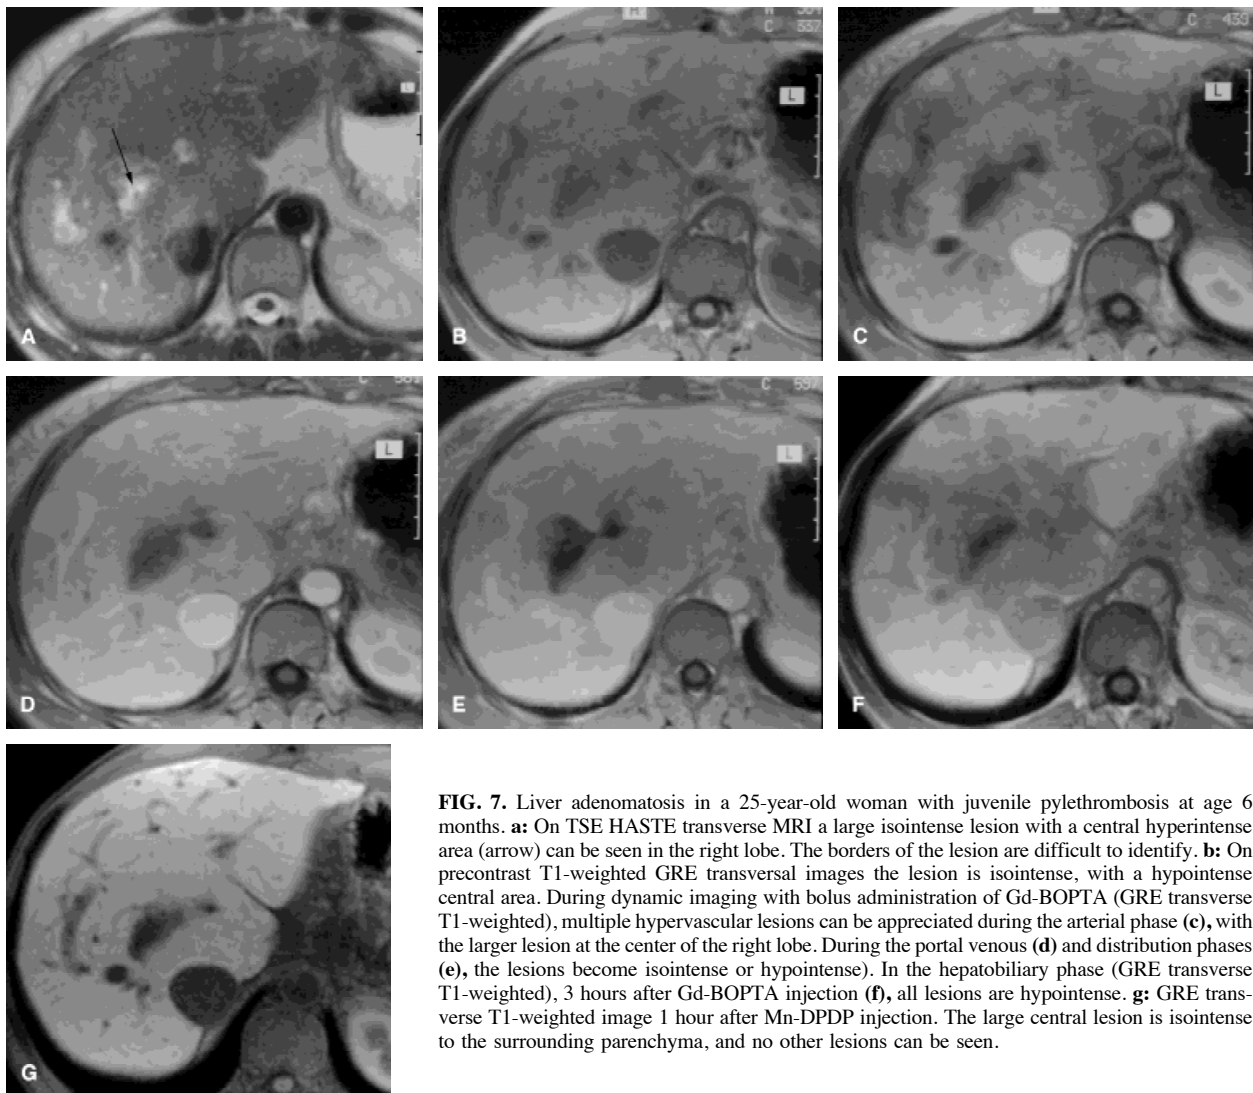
Liver adenomatosis in a 25-year-old woman with juvenile pylethrombosis at age 6 months. a: On TSE HASTE transverse MRI a large isointense lesion with a central hyperintense area (arrow) can be seen in the right lobe. The borders of the lesion are difficult to identify. b: On precontrast T1-weighted GRE transversal images the lesion is isointense, with a hypointense central area. During dynamic imaging with bolus administration of Gd-BOPTA (GRE transverse T1-weighted), multiple hypervascular lesions can be appreciated during the arterial phase (c), with the larger lesion at the center of the right lobe. During the portal venous (d) and distribution phases (e), the lesions become isointense or hypointense). In the hepatobiliary phase (GRE transverse T1-weighted), 3 hours after Gd-BOPTA injection (f), all lesions are hypointense. g: GRE transverse T1-weighted image 1 hour after Mn-DPDP injection. The large central lesion is isointense to the surrounding parenchyma, and no other lesions can be seen.
